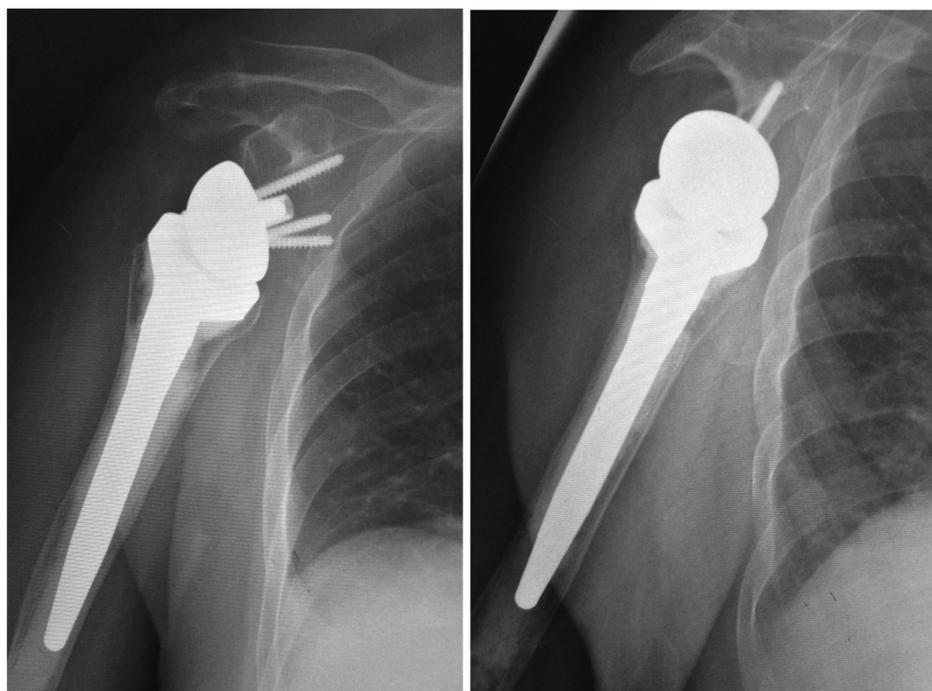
Postoperative radiograph of a patient who underwent reverse shoulder arthroplasty.
